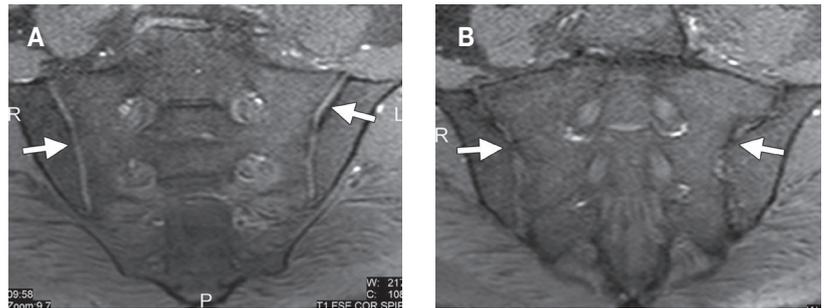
(a) Coronal oblique fat-suppressed T1-w MR image of the normal sacroiliac joint shows the smooth and parallel margins of the cartilaginous lower ventral portion (arrows). (b) Coronal oblique fat-suppressed T1-w MR image obtained more posteriorly shows the irregular edges of the fibrous or ligamentous upper dorsal portion (arrows).
